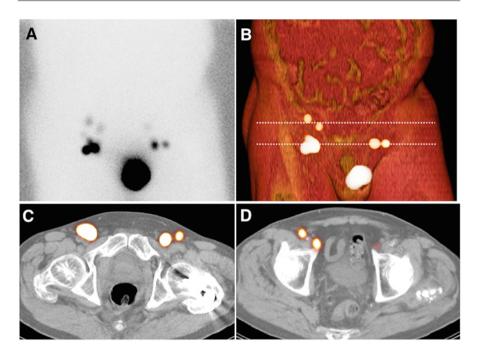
Lymphatic drainage in penile cancer. Anterior planar lymphoscintigraphy (\mathbf{a}) shows drainage from the central injection site to both groins. On SPECT/CT (volume rendered, \mathbf{b} and transversal slices \mathbf{c} , \mathbf{d}), inguinal sentinel nodes (*lower dotted line*) are clearly differentiated from second echelon iliac lymph nodes (*upper dotted line*)
